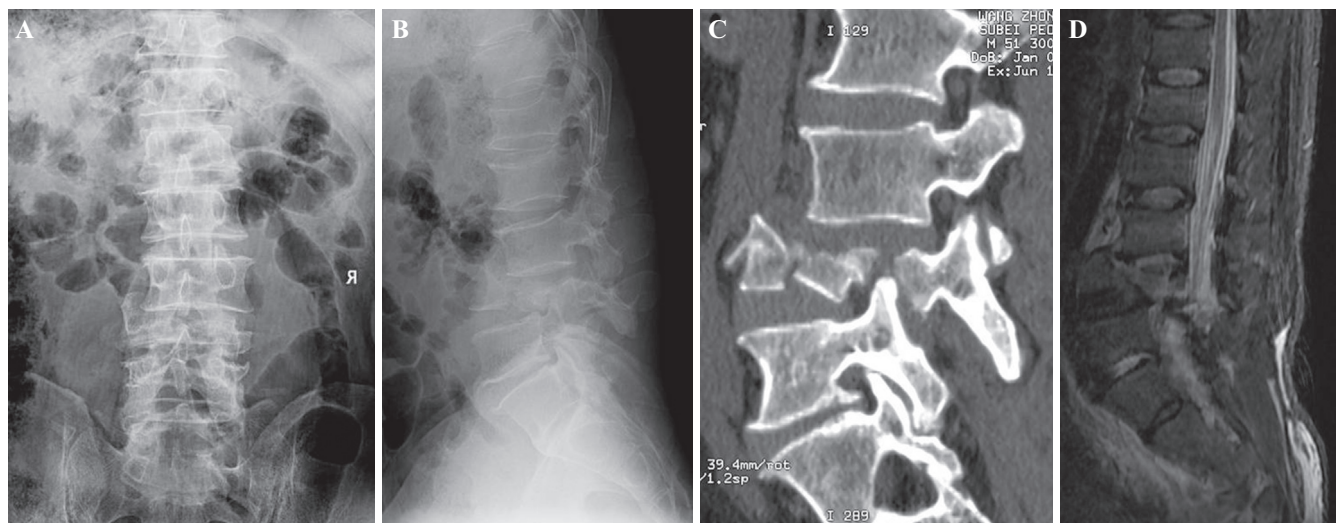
The preoperative images demonstrate burst fracture and dislocation of the L4 vertebral body: anteroposterior (A) and lateral (B) radiographs, sagittal computed tomographic reconstruction (C), and magnetic resonance imaging (D).
